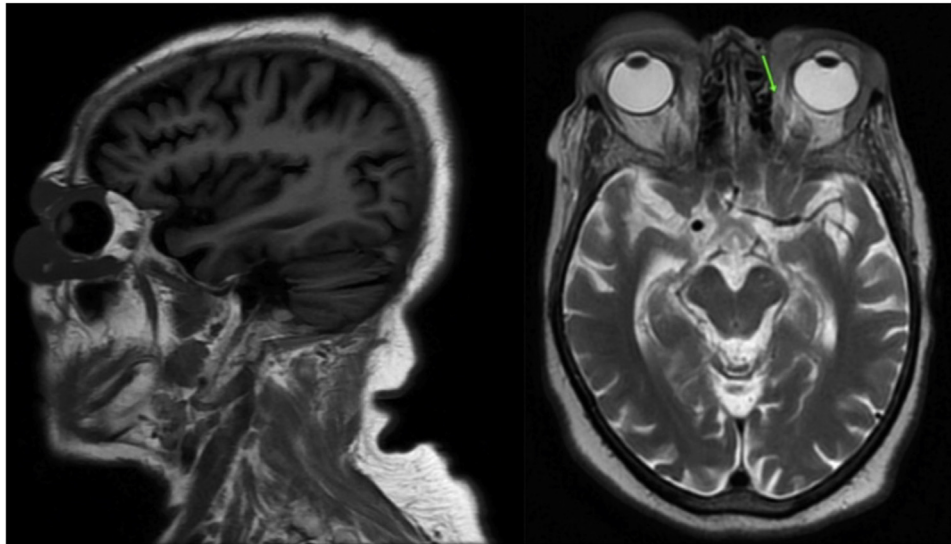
Magnetic resonance imaging of the facial mass: transverse and sagittal section of the lesion processes.
